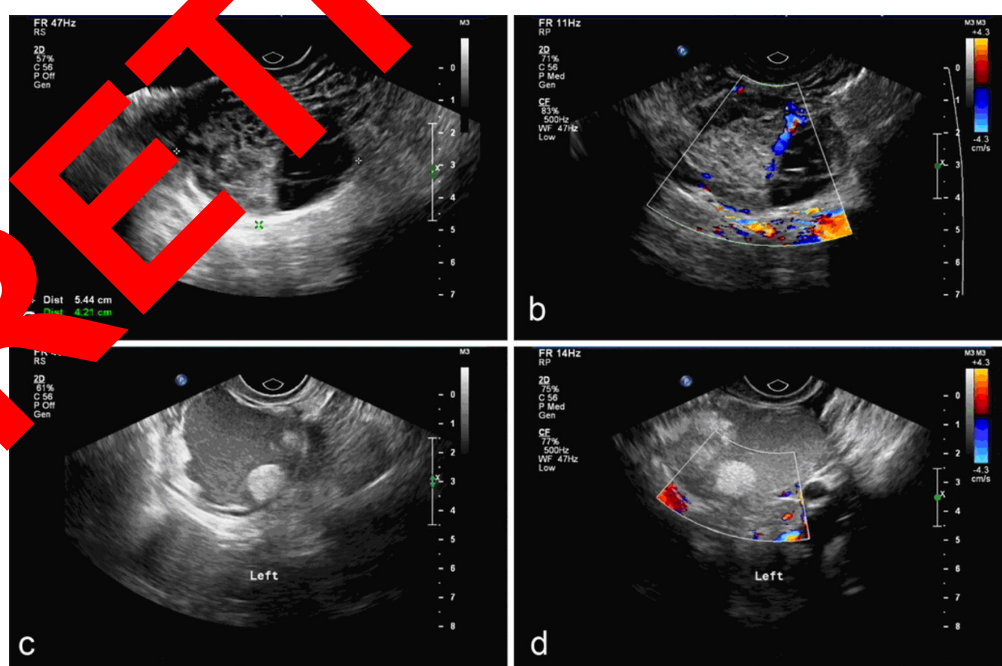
Ultrasound images of benign and malignant ovarian tumours. A: Ultrasound scanning image of an epithelial ovarian tumour. B: Image of a colour Doppler ultrasound to assess the blood flow of an epithelial ovarian tumour. C: Ultrasound scanning image of a benign tumour (fibroadenoma). D: Peripheral blood flow of a benign tumour.
